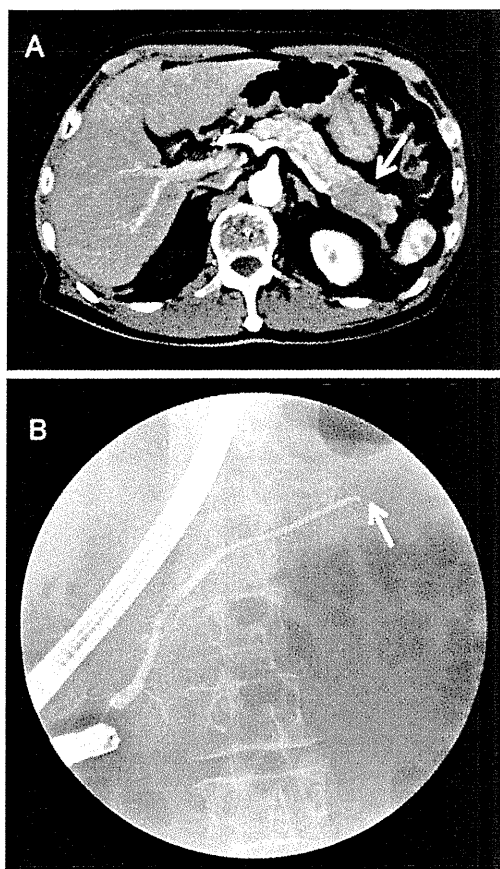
Dynamic abdominal CT scans in arterial phase showed a low-density mass (*arrow*) measuring 40×23 mm in the tail of the pancreas (a). ERCP showed an obstruction of the MPD (*arrow*) at the site of the pancreatic mass (b)
